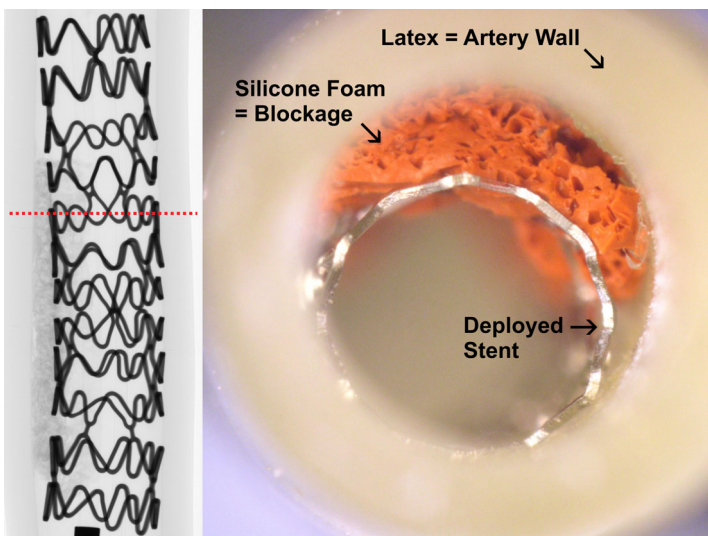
Photograph of a stent implanted in a model artery. The inset on the left is an X-ray projection of the implanted stent, which is 13mm long. The dashed line shows the position of the tomography slice shown in Fig. 2.
